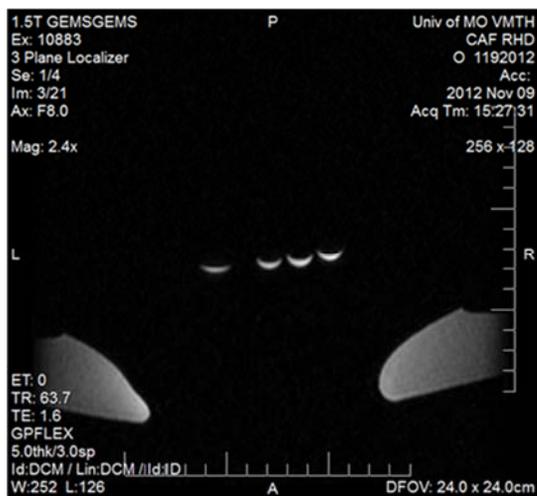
MRI Images of Au@Fe solutions at different concentrations
